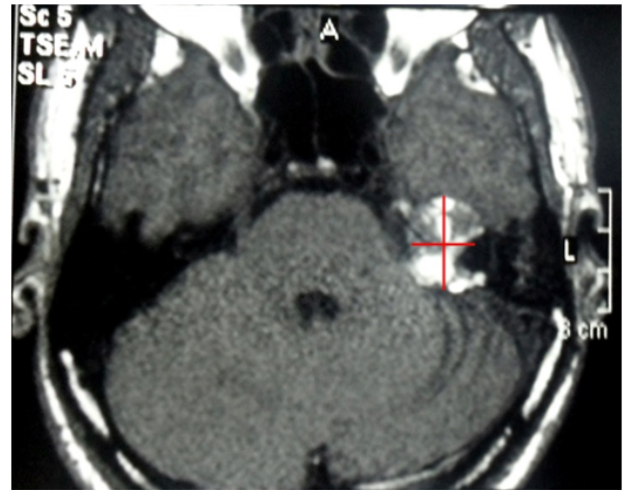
Magnetic Resonance Imaging (MRI) of left CP angle shows tumor measuring 3x2cm and extends into the left middle cranial fossa 2x2x1cm, enhancement of adjacent dura.
